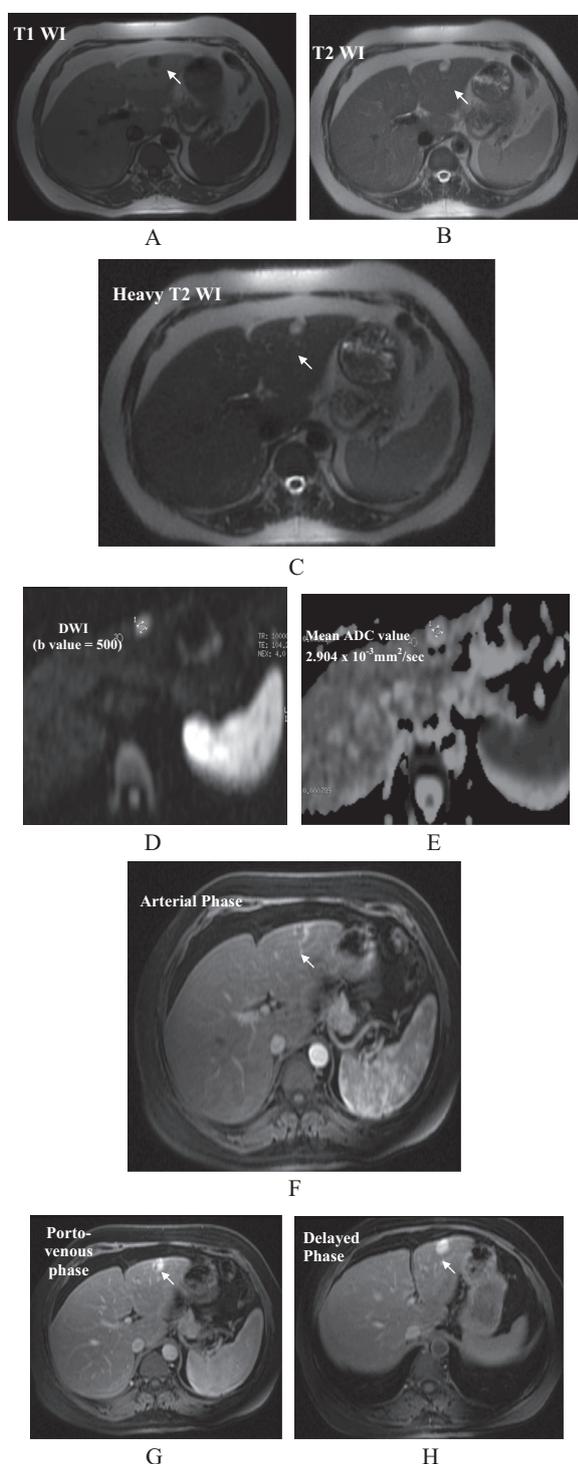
(A–H) Female patient aged 51 year, presented with hyperechoic left hepatic lobe focal lesion during US checkup. MRI study revealed a small left hepatic lobe subcapsular focal lesion exhibits hypointense SI on T1WI, hyperintense SI on T2 and heavy T2 weighted images. The lesion appeared hyperintense on diffusion study as well as at the ADC map with mean ADC value = 2.9×10^{-3} s/mm². The lesion showed incomplete ring of peripheral nodular enhancement at the arterial phase after contrast injection with gradual filling at the porto-venous phase and complete filling with contrast at delayed images. The lesion showed the typical MRI findings of the hemangioma.
